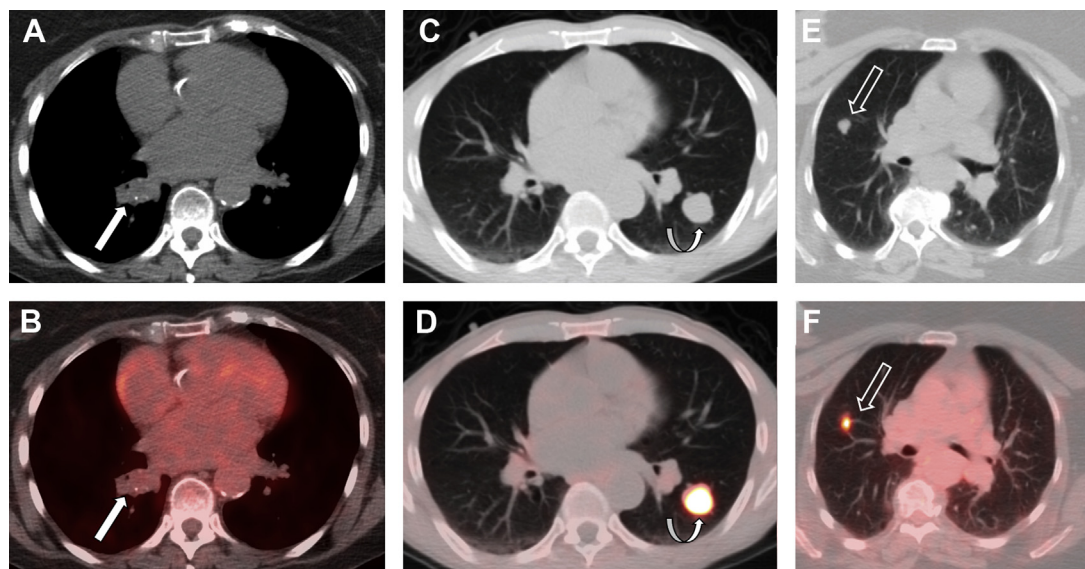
Three patients with lung carcinoid tumors. Axial CT (A) and fused ^{18}F FDG-PET/CT (B) images demonstrate a right-sided endobronchial lesion (*arrow*) with calcifications and low FDG uptake, biopsy-proven to represent a typical lung carcinoid. Axial CT (C) and fused ^{68}Ga DOTATATE-PET/CT (D) images from a different patient demonstrate a well-circumscribed left nodule (*curved arrow*) with very high tracer activity, consistent with a typical lung carcinoid. Axial CT (E) and fused ^{18}F FDG-PET/CT (F) images from a third patient demonstrate increased tracer activity in a peripheral right lung nodule (*open arrow*), which was subsequently biopsied and found to represent an atypical lung carcinoid.
